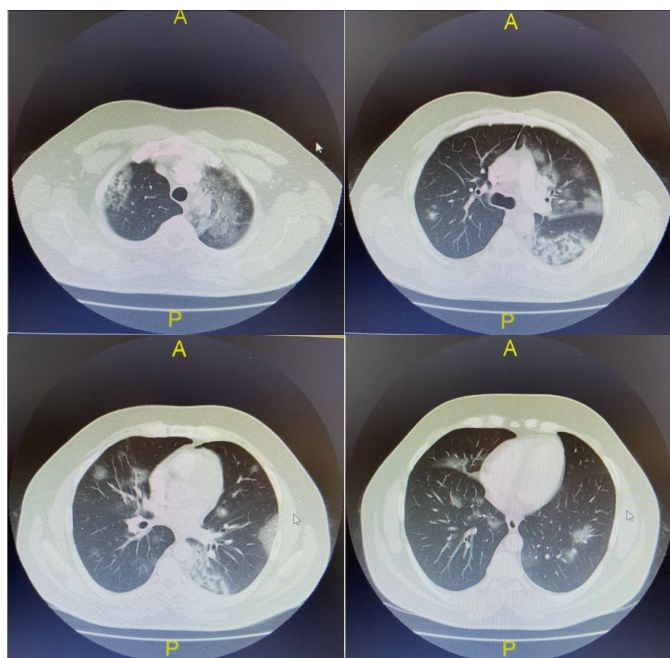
Initial computed tomography pulmonary angiogram: diffuse multilobed, multifocal, predominantly peripherally located, ground glass consolidations with approximately 25-50% of lung parenchyma being affected
